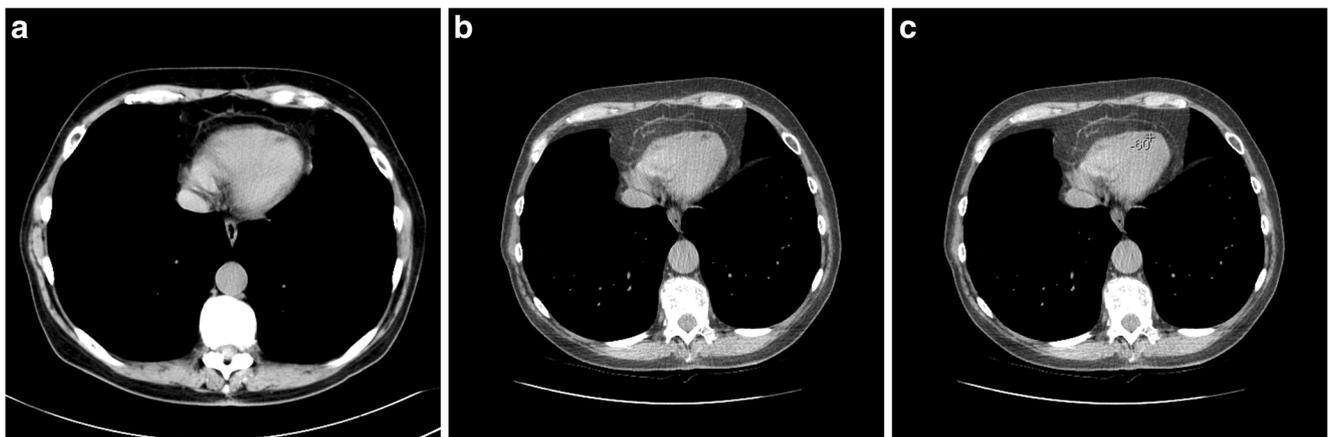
Non-contrast 5-mm axial CT demonstrates subendocardial left ventricular myocardial fat in the apical interventricular septum and in the right ventricular free wall in a 68-year-old female without a history of MI (a). Nine years later, the same distribution of myocardial fat is noted
